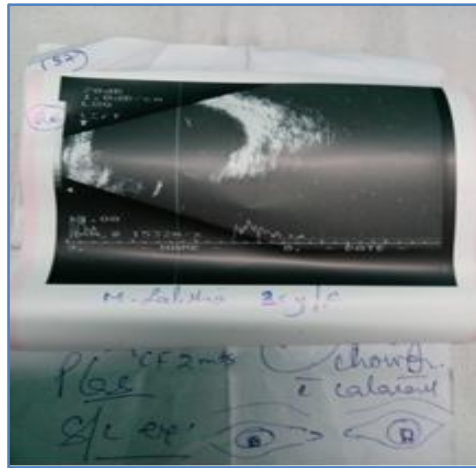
Ultrasonography of the globe shows Coloboma choroid
